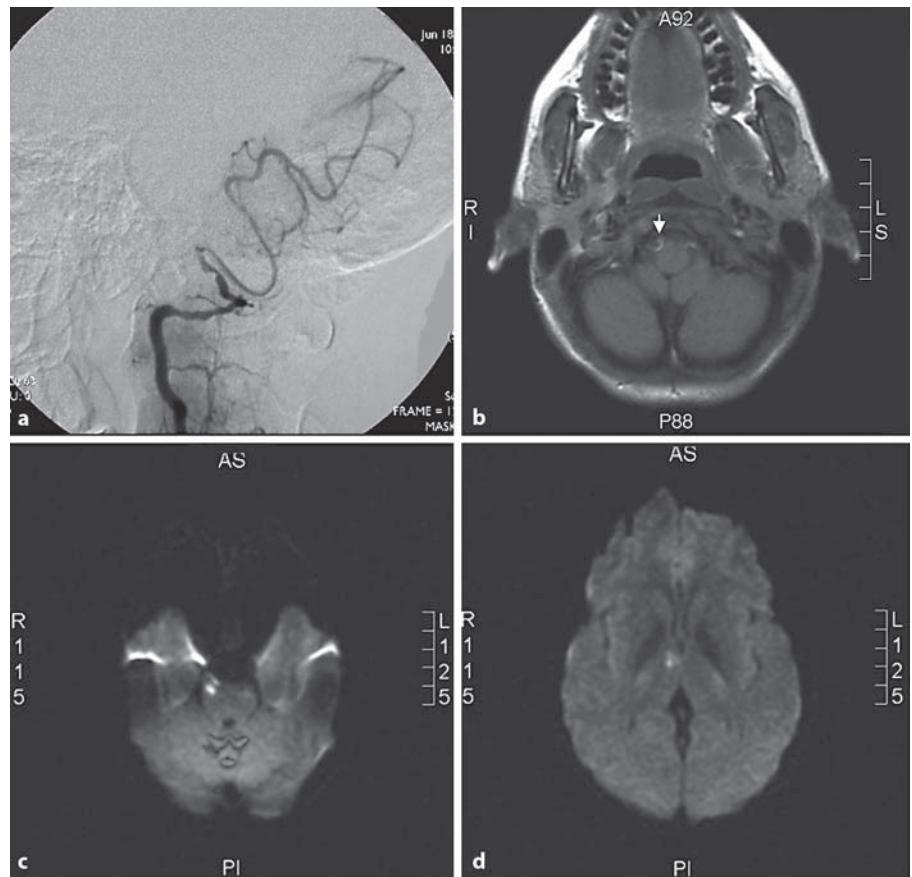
Dissection of the right vertebral artery on cerebral angiography (a) and MRI (b) with right ischaemic lesions in the pons and thalamus on diffusion-weighted imaging sequences (c, d).
